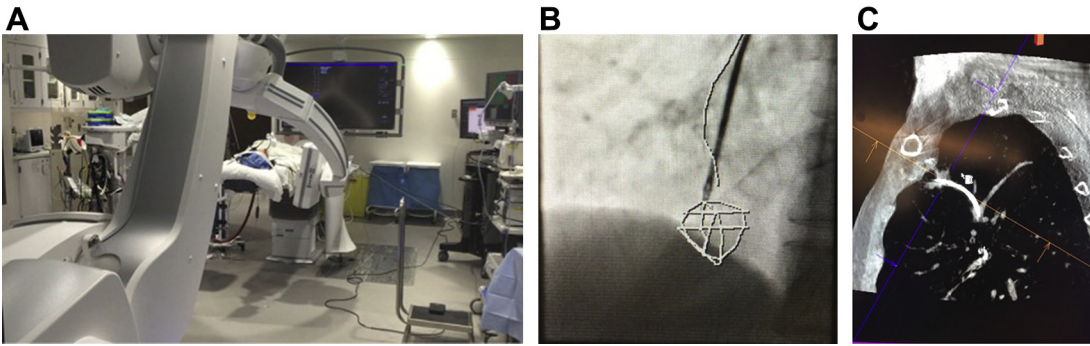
(A) Cone beam CT preparation for image acquisition. Note that all personnel are out of the room, and the bronchoscopy and other instruments are separated from the system and secured. (B) Cone beam CT with target overlay on the fluoroscopy images with pathway (DynaCT Siemens). (C) Image captured from cone beam CT of a peripheral TBNA directed into a spiculated lesion in the left upper lobe, using ENB.
